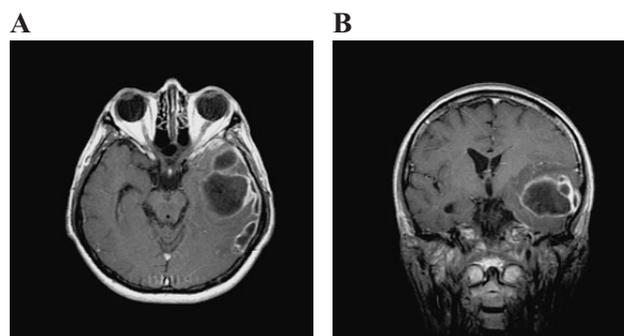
Brain magnetic resonance imaging scan T1-weighted MRI axial view (A) and coronal view (B) post-Gadolinium-DTPA administration shows multiple and multiloculated abscesses at the left temporal lobe.
